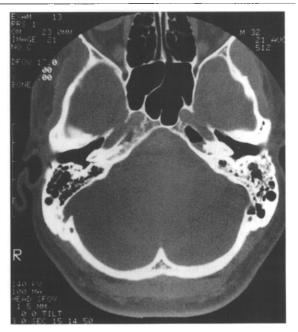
Sinus barotrauma affecting the sphenoid and mastoid regions. Computed tomography (CT) scans have replaced traditional radiology in identification of problematic cases. The CT scan of the brain on bone setting through the skull base shows a fluid level within the antromedial air cell of the left petrous temporal bone line. In addition, there is loss of pneumatization of the left mastoid air cells.
